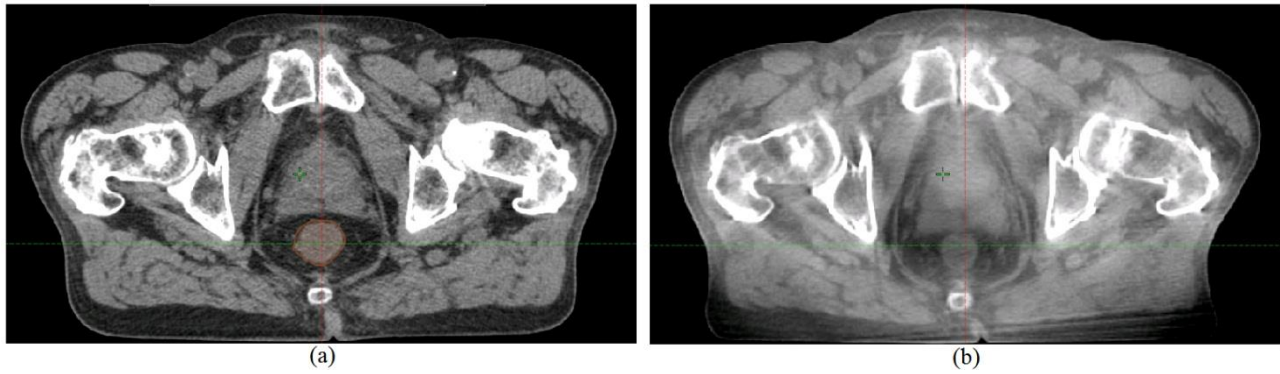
(a) CT and (b) CBCT scan relatively easy to validate.
